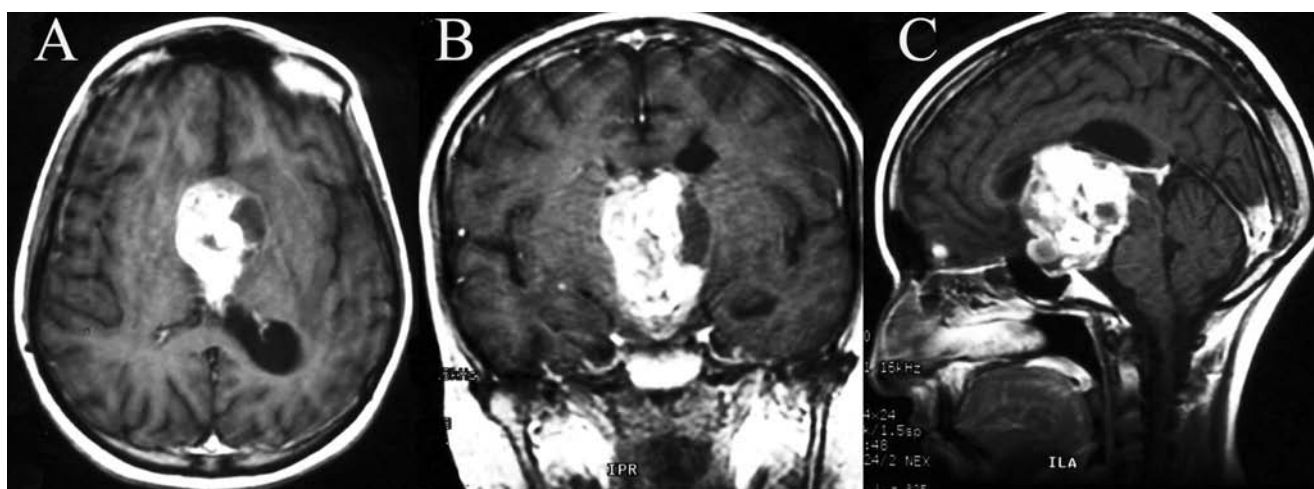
Brain MR T1-weighted axial (a), coronal (b) and sagittal (c) images showing a hypothalamic- chiasmatic tumor with disomogenous contrast enhancement, irregular borders and slight perilesional edema.
